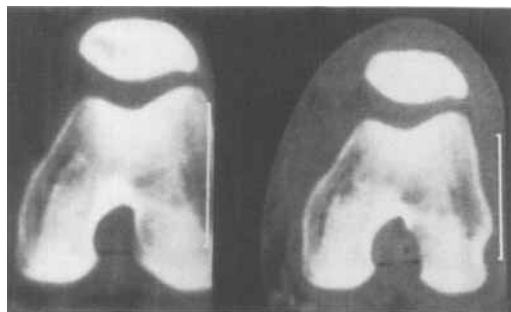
The anterior notch diameter was measured on a CT scan before (left) and after (right) notch plasty.
